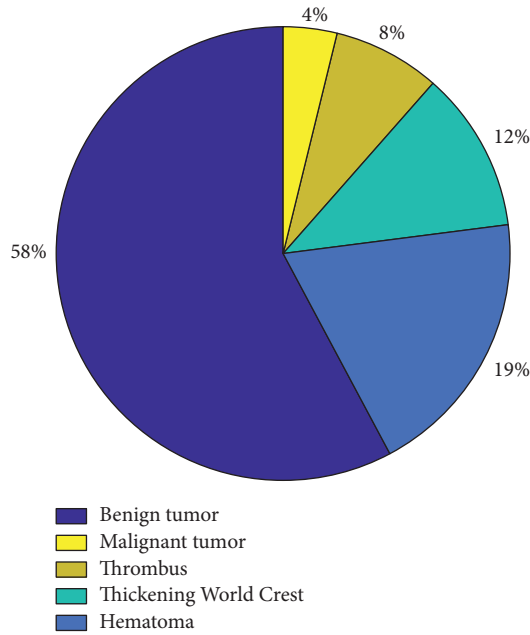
Transesophageal echocardiography results.
